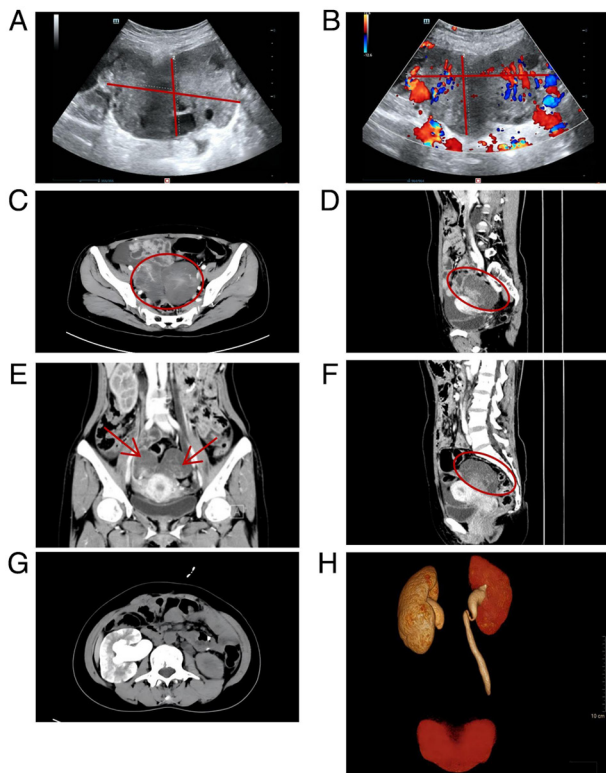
Ultrasound, CT, CTU and three-dimensional reconstruction imaging findings. (A) Ultrasound performed in September 2023 showed a 108x65 mm mass lesion thought to originate from the ovaries that had no clear relationship with the uterus. (B) Color Doppler flow imaging showed markedly increased flow signals bright in the lesion. (C) Enhanced abdominal CT imaging showed a hyperdense mass lesion of 110x67x47 mm, which had a cystic-solid component. (D-F) The lesion was visualized using contrast-enhanced CT: (D) Left and (F) right sagittal views, and (E) coronal view. (G) Multi-slice spiral CTU and intravenous pyelogram imaging showed right renal pelvis dilatation and ureteral stenosis. (H) Right ureteral obstruction was not visible on the CT urography. CT, computed tomography; CTU, CT urography.
